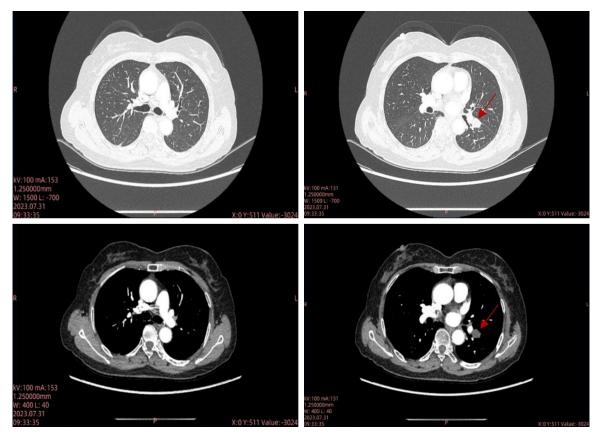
Contrast-enhanced CT scan 3 months after BAE showed that the size of the left lung nodules decreased significantly.
